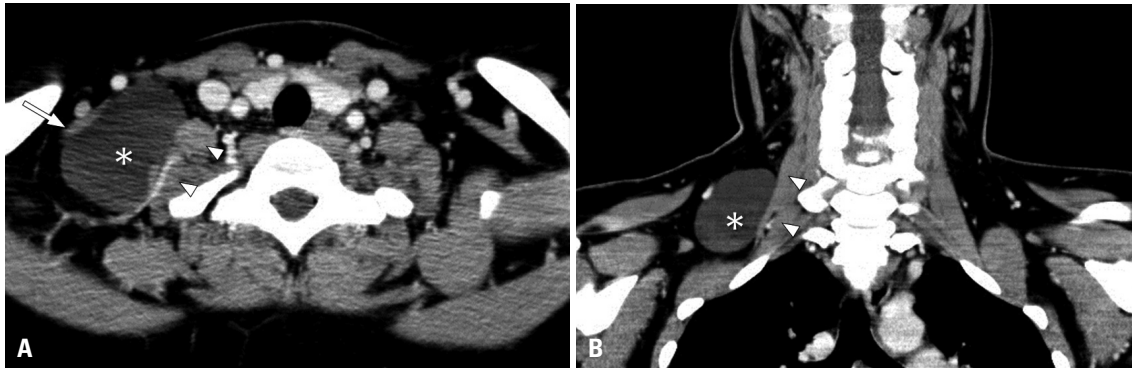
Computed tomographic images of 24-year-old woman showed a 5.5 cm-sized unilocular thin-walled cystic lymphatic malformation (asterisk) in the posterior triangle of the right neck. The cyst is located between the Inferior belly of omohyoid muscle (arrow) and scalene muscles (arrowheads). (A) Axial view. (B) Coronal view.
